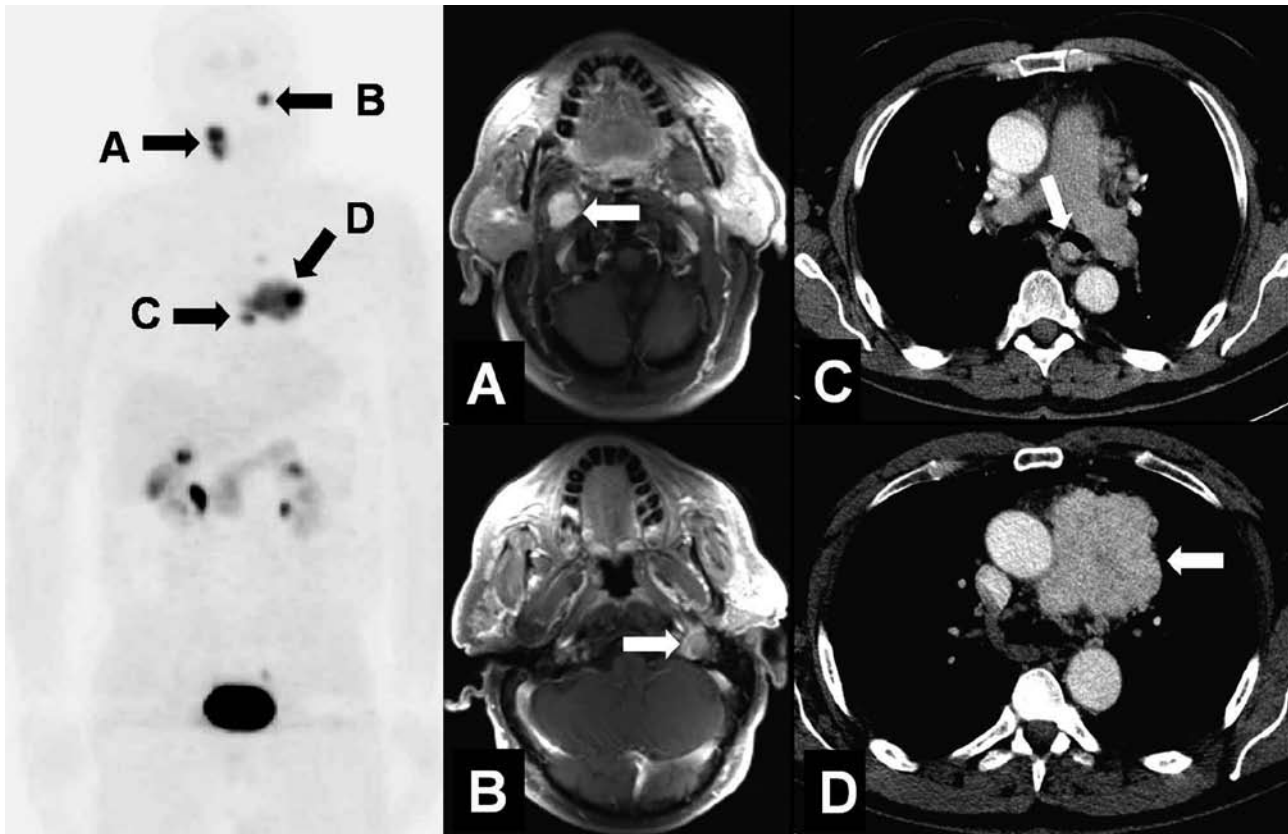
Paraganglioma syndrome type 1. The left panel represents an ¹⁸F-DOPA image with at least 4 tumours identified. The right panel represents the MRI images of the 4 tumours: right carotid paraganglioma (A), left tympanic paraganglioma (B), large upper mediastinal (C) and small paratracheal paraganglioma (D).
